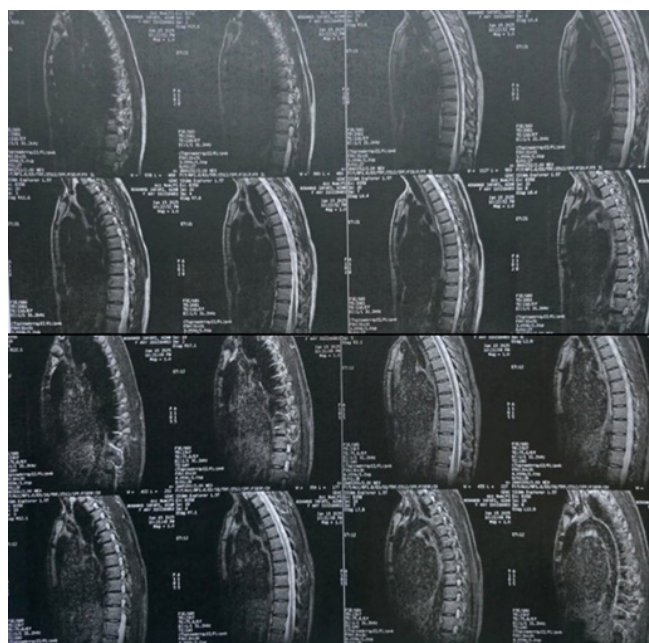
After exosome, Thoracic spine MRI with contrast was done as well. Technique was sagittal T1, T2/W and selected axial T1/W images were performed. Reveal no CSF block or extrinsic pressure in thoracic region. Vertebral bodies, disc spaces, bone marrow signal, posterior elements, dural sac and nerve root canals appear normal. In post-Gd-DTPA injection images, no abnormal enhancement is seen.
